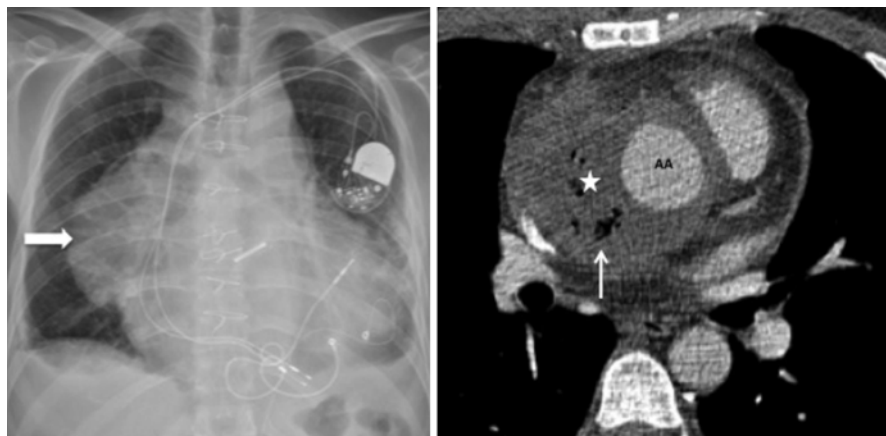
A 67-year old patient developed fever with chest pain 1 week after complex cardiac surgery. CXR shows widening of mediastinal silhouette (*arrow*). Intravenous contrast medium enhanced CT demonstrates a large mediastinal collection (*white star*) with locules of air (*white arrow*), intimately related to the ascending aortic (AA) interposition graft. Appearances are those of mediastinal abscess
